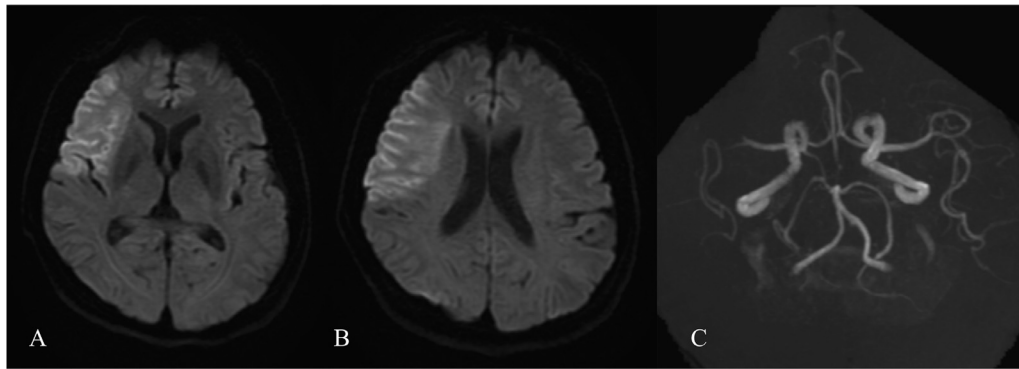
Magnetic resonance imaging on presentation showed acute ischemic stroke in the right hemisphere (A, B). Magnetic resonance angiography showed occlusion of the M2 segment of the right middle cerebral artery (C).
